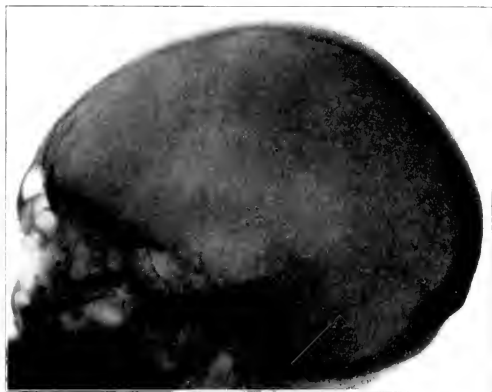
(Case 2).—Roentgenogram of the sella turcica.
